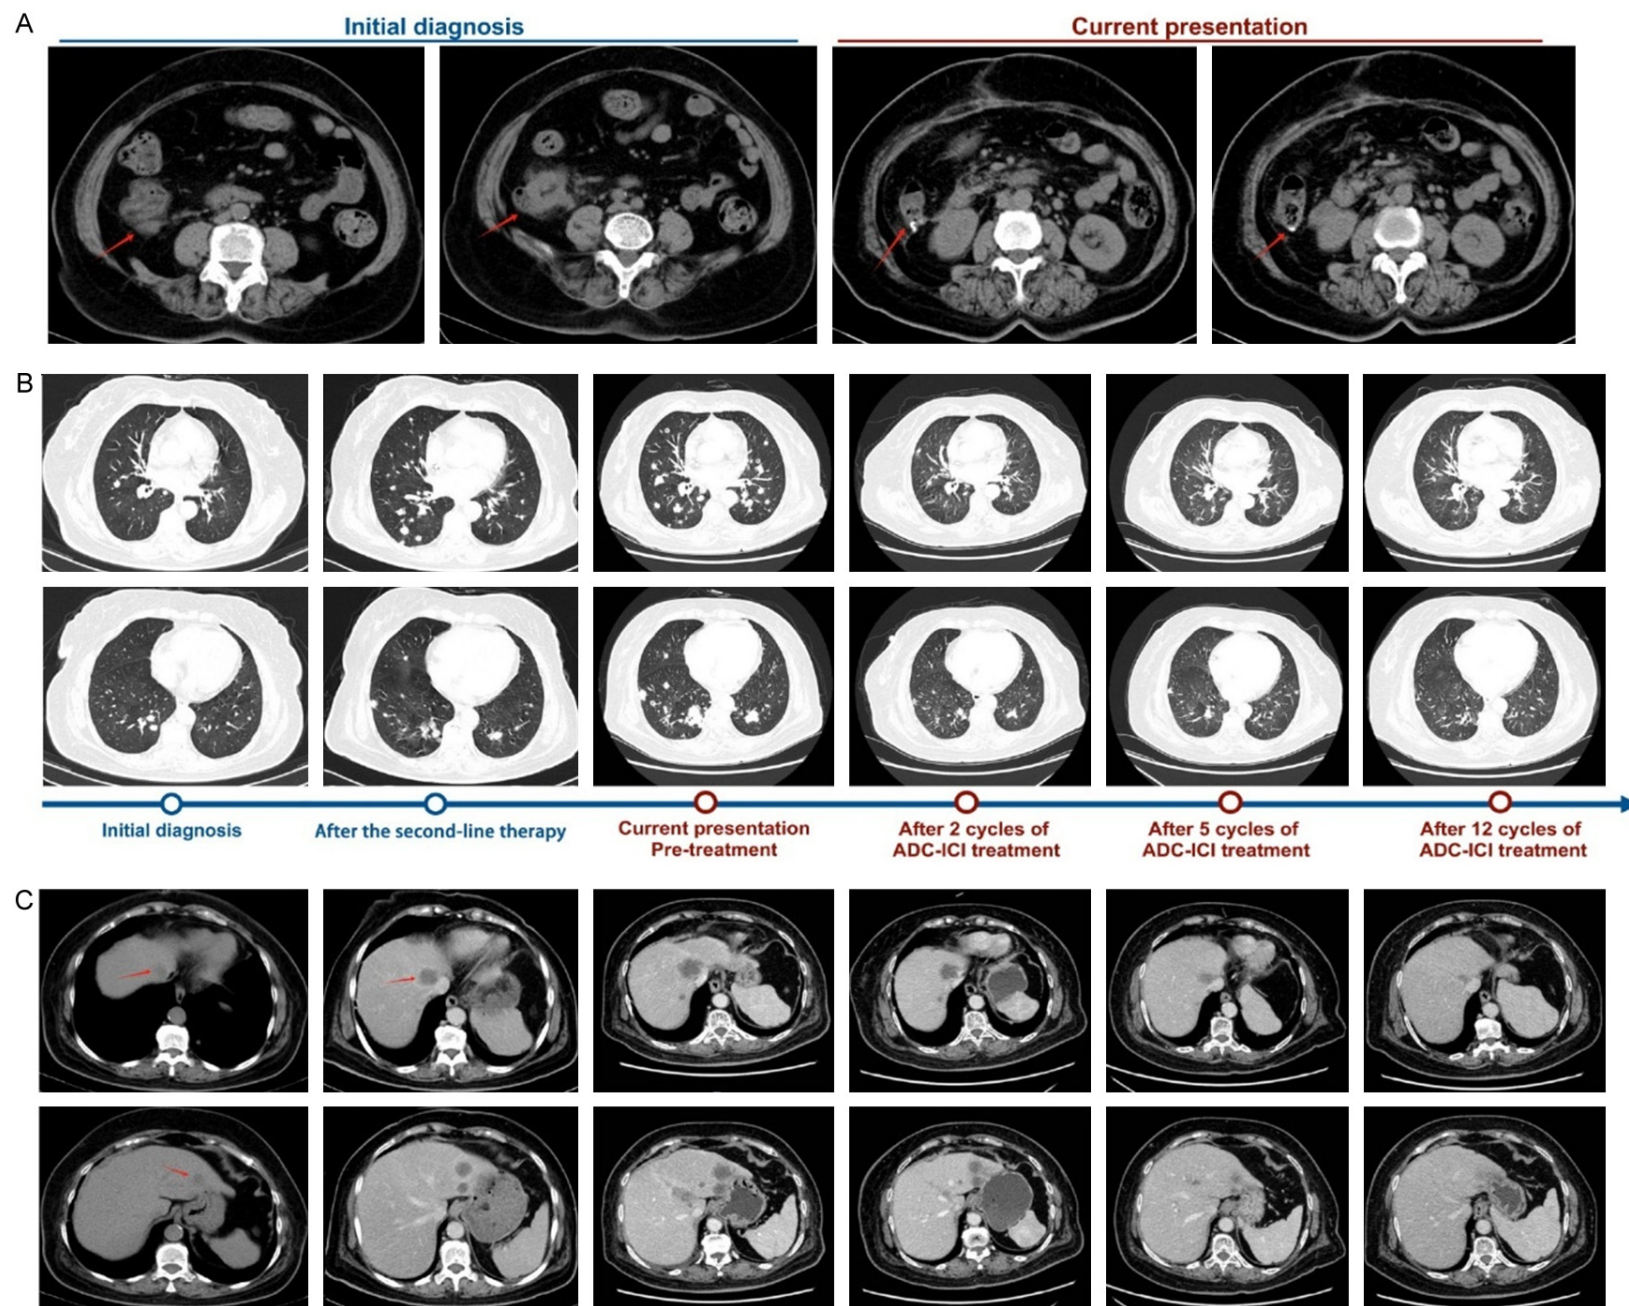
Tumor changes during treatment. A. Abdominal computed tomography (CT) scans at initial and current diagnosis show the primary right-sided colon tumor and postoperative changes after surgical resection (arrow). B. Chest CT scan show changes in pulmonary metastases during treatment. At the current presentation, bilateral multifocal pulmonary masses, some with cavitation, were evident. After five cycles of serplulimab in combination with T-DXd, significant shrinkage and partial disappearance of the pulmonary lesions were observed, correlating with a partial response (PR). C. Abdominal CT scan show changes in liver metastases. After treatment with serplulimab and T-DXd, the liver lesions showed significant regression, achieving PR. Abbreviations: ADC, antibody-drug conjugate; ICI, immune checkpoint inhibitor; ADC-ICI, combination treatment with serplulimab and T-DXd; CT, computed tomography; PR, partial response.
